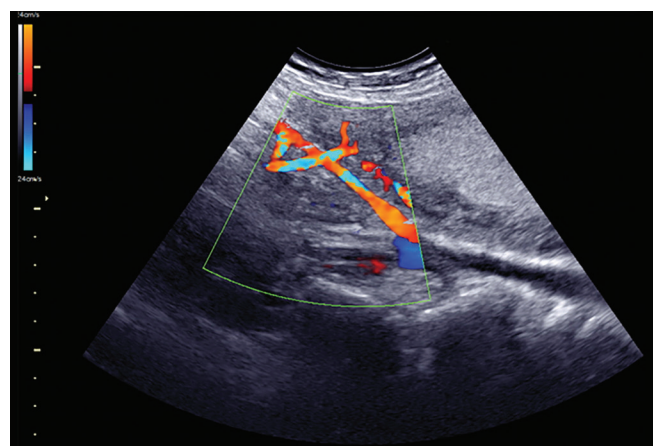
Color Doppler mapping of the uterine artery. This smaller artery is crossing over larger vessels, which are iliac artery and vein
